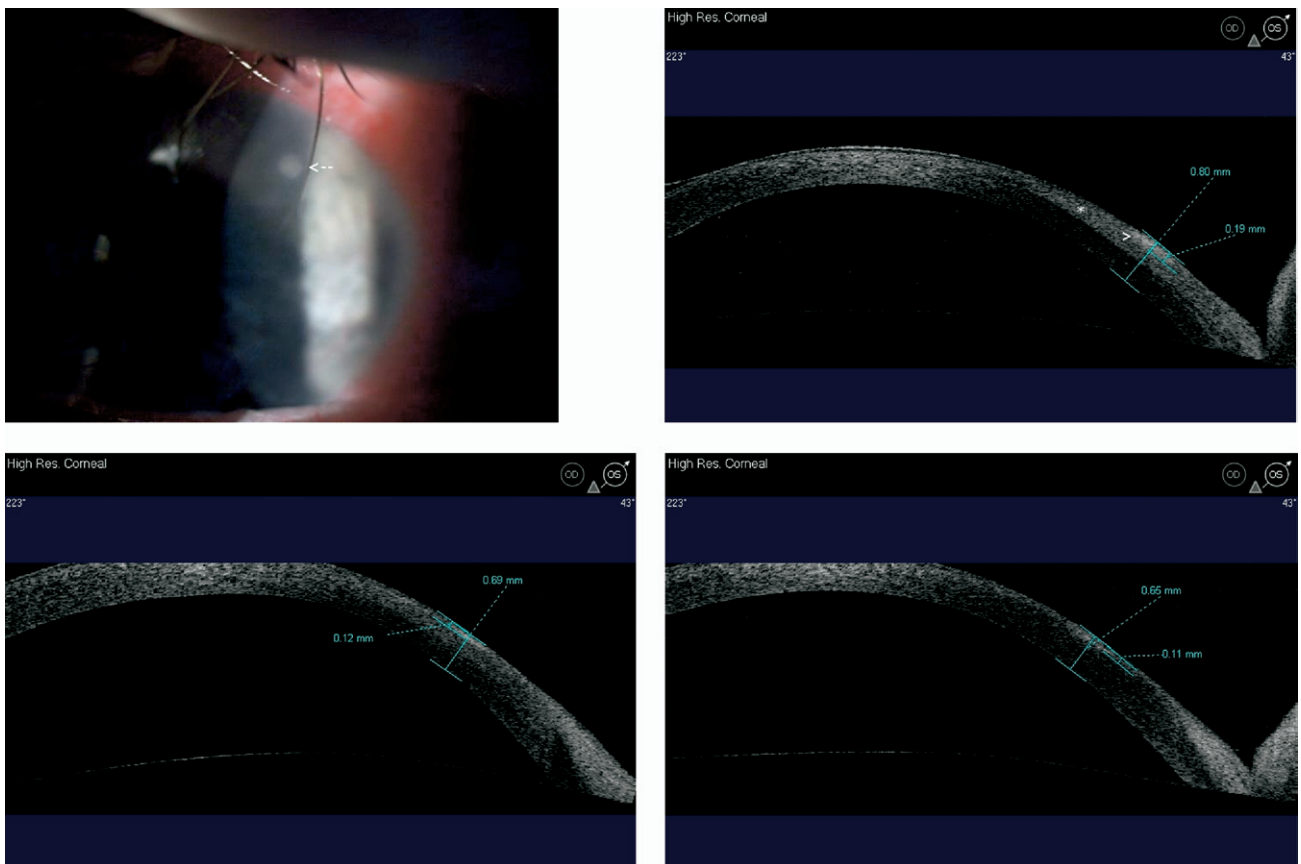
Images demonstrating contact lens-associated keratitis, including serial high-resolution anterior segment optical coherence tomography (AS OCT) images at the 43-degree meridian. (Top left) Anterior segment photograph obtained at presentation showing small corneal infiltrate (arrow). (Top right) AS OCT image obtained at presentation showing superficial stromal infiltrate (>) with edema in the anterior stroma (*). (Bottom left) AS OCT image obtained two days after presentation showing reduction of infiltrate and corneal thickness (CT). (Bottom right) AS OCT image obtained two weeks after presentation showing further reduction of CT and the presence of superficial stromal scarring.
